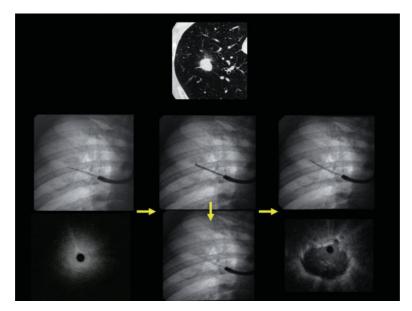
Confirmation of the location of the guide sheath within the lesion. This is a method of accurately placing the guide sheath within a peripheral pulmonary lesion. Once a peripheral lesion has been delineated using EBUS, at the point the lesion appears at its largest and clearest, the assistant should withdraw the ultrasonic probe about 2–3 mm at a time
